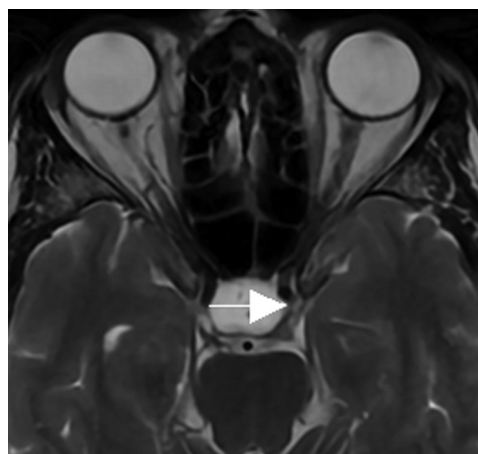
The picture shows the width of the sella turcica in the axial MR image.
